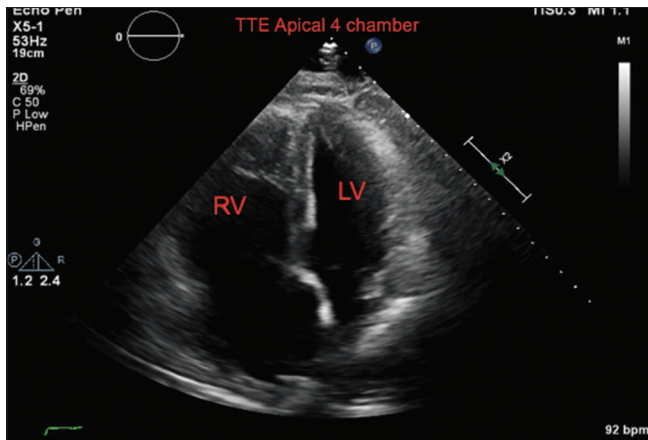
Flattened interventricular septum in apical four-chamber transthoracic echocardiogram view with enlarged right ventricle suggesting right ventricle failure
